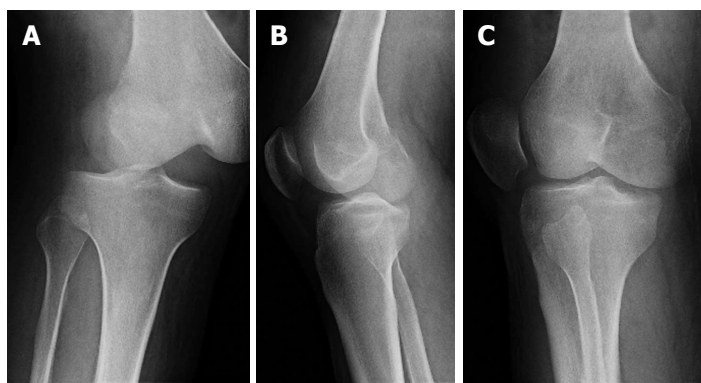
Supine radiographs showing posterolateral dislocation of the knee. A: AP; B: Lateral; C: Oblique. Note similar projections (AP or lateral) of both the tibia and femur are not seen in any single view. AP: Anteroposterior.
